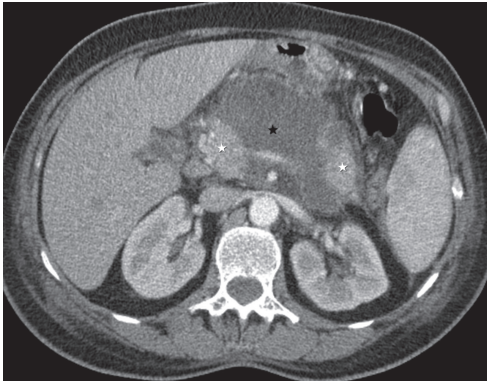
A 42-year-old woman with central gland necrosis. Contrast-enhanced CT depicts necrosis of the neck and body of the pancreas (black star) among the viable pancreatic head and tail (white stars). This patient is at risk for having a pancreatic duct disruption with increased need for intervention.
